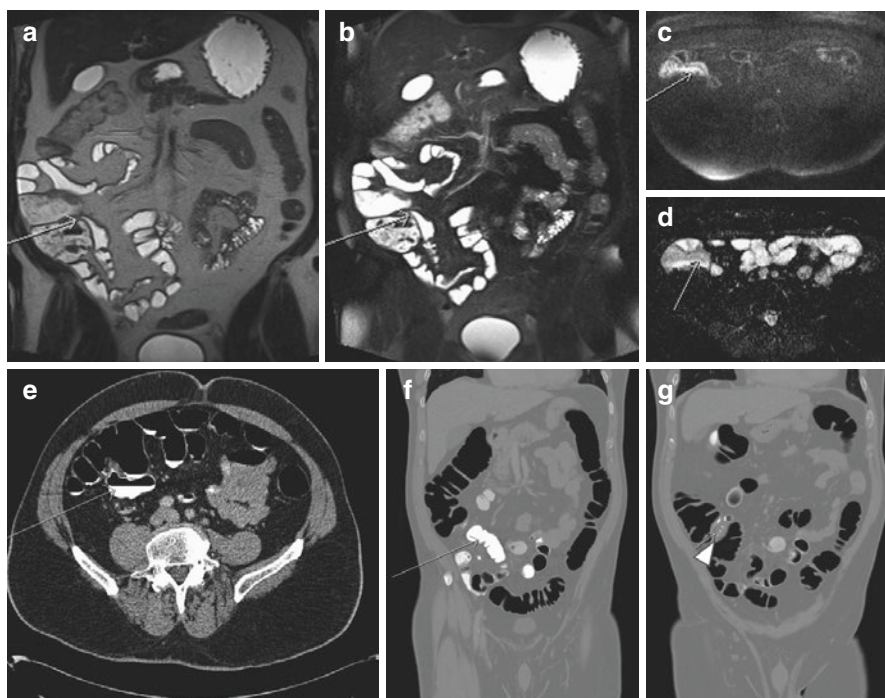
False positive DWI, of the terminal ileum (arrows), which is partially collapsed as seen on coronal HASTE without (a) and with (b) fat saturation, although little in the way of mural thickening. Apparent restricted diffusion as demonstrated on the DWI (c) and corresponding ADC map ($B = 600 \text{ s/mm}^2$) (d). The terminal ileum and ileocaecal valve (arrow head) were normal at CT colonography (e–g)
